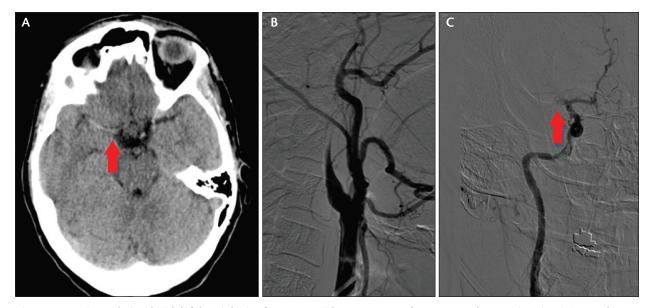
Patient admitted with left hemiplegia after a car accident. Corresponding CT scan shows string sign (A). DSA shows typical image of carotid dissection (B). There was leptomeningeal flow from the ipsilateral posterior cerebral artery. The right ICA was permeabilized, and the image of the thrombus in the middle cerebral artery is viewed (C).
